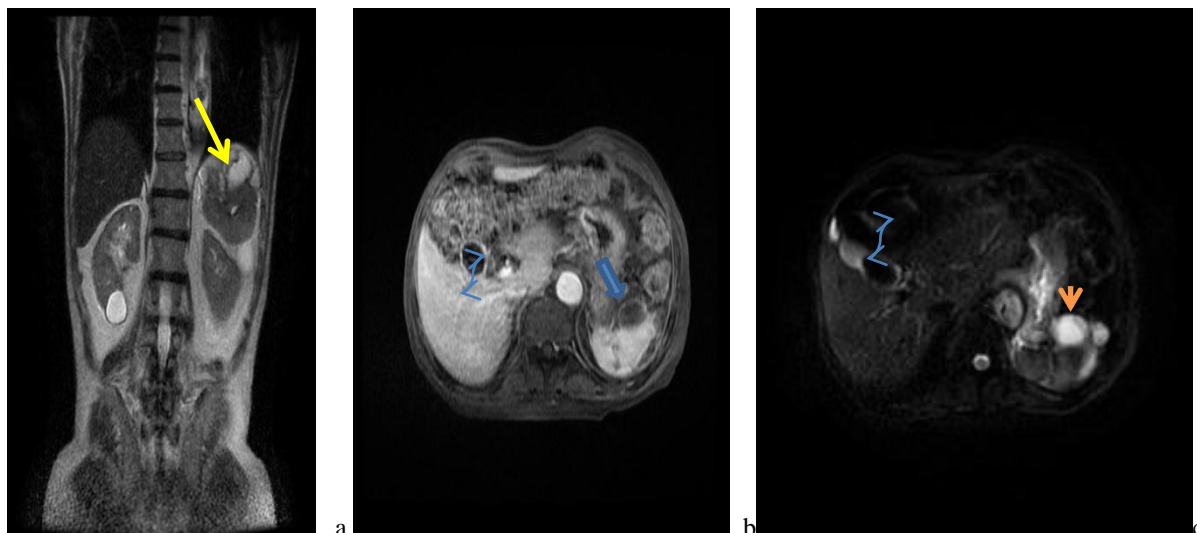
The MRI images showed that the intrasplenic and subcapsular lesions are heterogeneously hyperintense on T2WI coronal images (yellow arrow), with restriction on the diffusion sequence (c) (orange arrow head). On the contrast-enhanced MRI images (b), peripheral wall enhancement is noted (double blue arrow). Additionally, the signal void of the gallstone is visible on all sequences (curved tail arrow)
